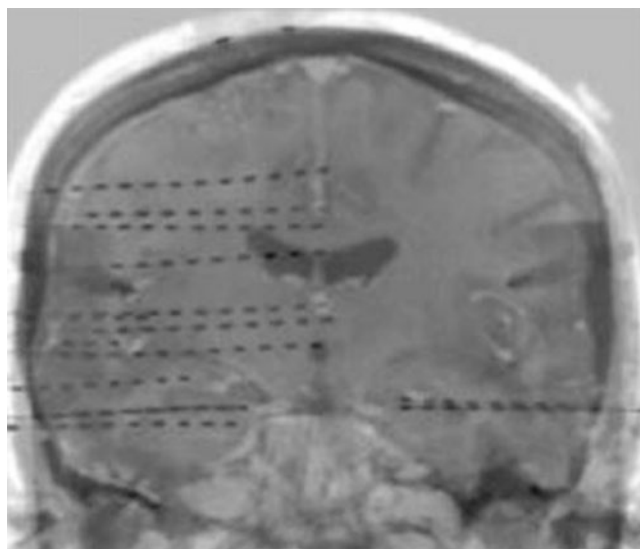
Live fluoroscopic image fused with preoperative MR image during implantation of SEEG electrodes. Note the insertion of hippocampal electrodes bilaterally. The intraoperative images provide the surgeon with an additional degree of certainty and precision regarding the final position of every trajectory. (From Alomar et al. [83]; with permission)
